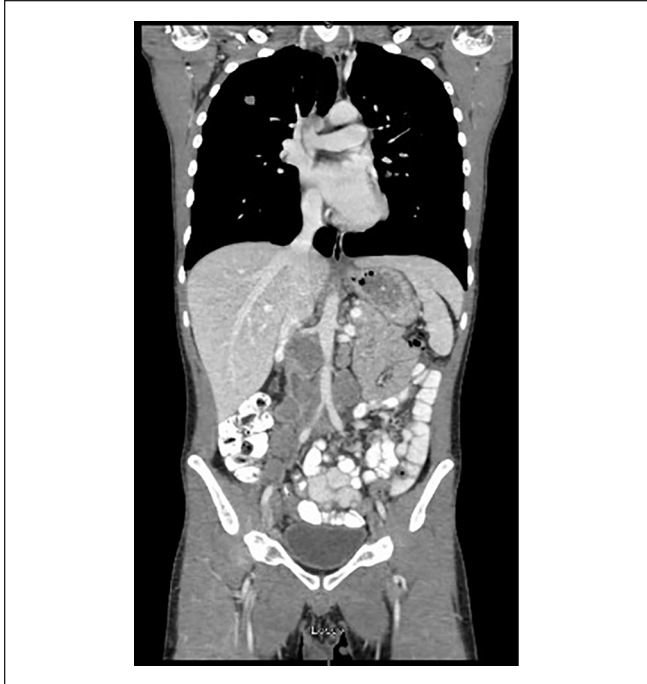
Coronal computed tomography (CT) scan of the chest, pelvis, and abdomen with contrast showing multiple pulmonary nodules and pelvic/retroperitoneal lymphadenopathy.
